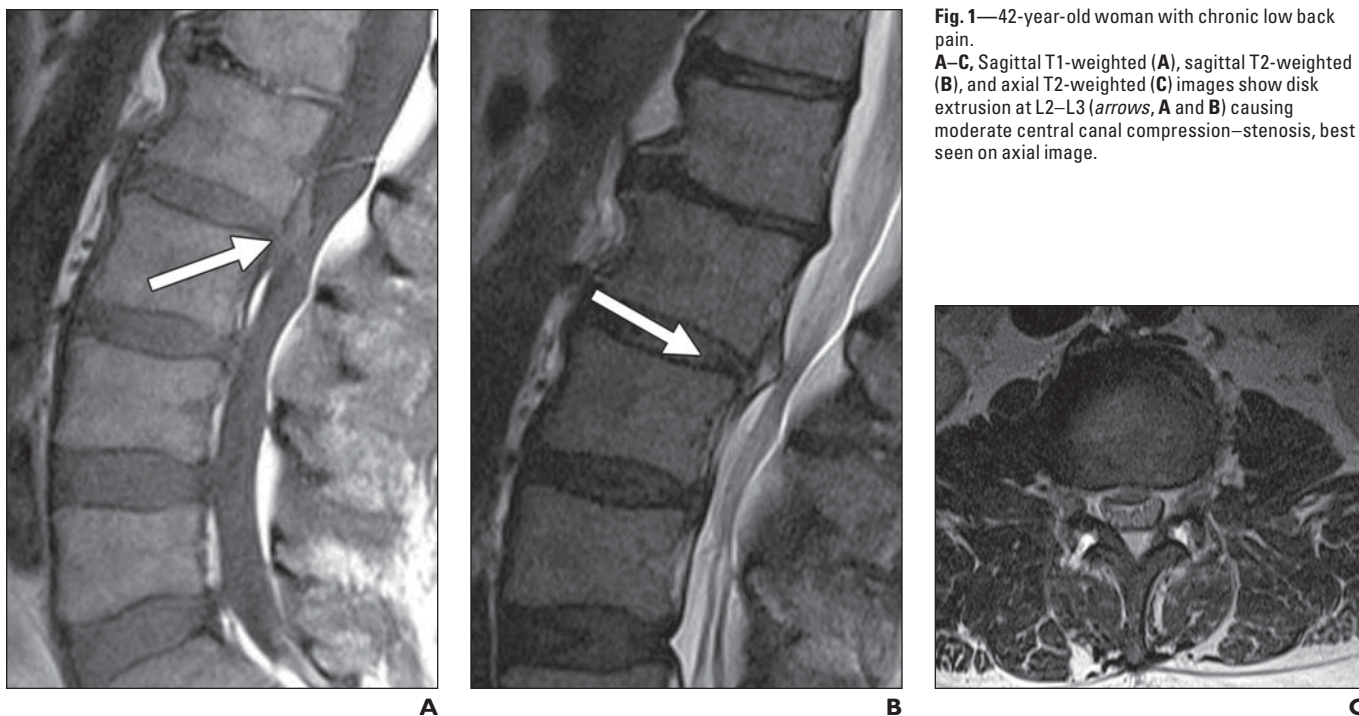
42-year-old woman with chronic low back pain. A–C, Sagittal T1-weighted (A), sagittal T2-weighted (B), and axial T2-weighted (C) images show disk extrusion at L2–L3 (arrows, A and B) causing moderate central canal compression–stenosis, best seen on axial image.
